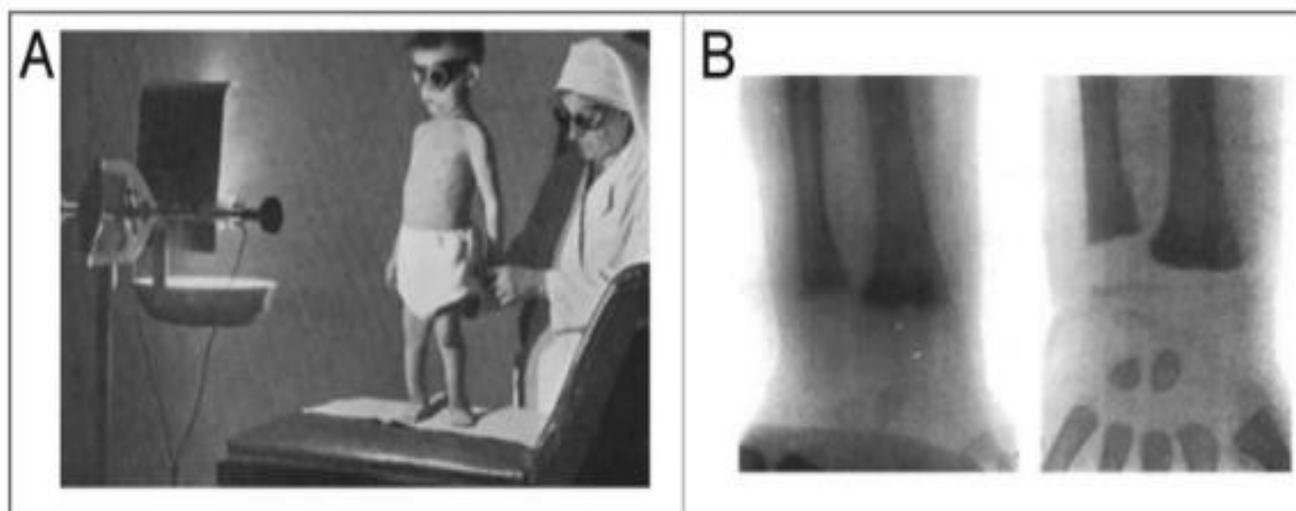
UV radiation therapy for rickets. (A) Photograph from the 1920s of a child with rickets being exposed to artificial UV radiation. (B) Radiographs demonstrating florid rickets of the hand and wrist (left). The same hand and wrist were taken after a course of treatment with 1-h UV radiation 2 times/week for 8 weeks showing mineralization of the carpal bones and epiphyseal plates (right). Holick, copyright 2006. Reproduced with permission. [10]
